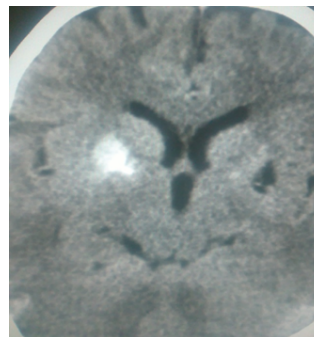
CT Brain Plain showing hyper dense area involving right Basal Ganglia. An abnormal signal of the right striatum, in the caudate nucleus and putamen, characterized by hyperintensity on T1 sequences, suggestive of diabetic striatopathy.
